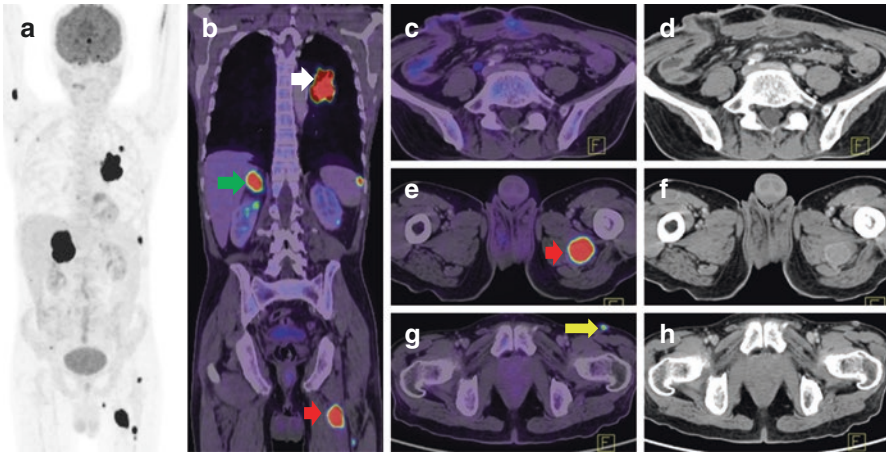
A 64-year-old male patient diagnosed with adenocarcinoma of colon post-surgery and adjuvant chemotherapy, 18F-FDG PET/CT revealed no abnormal lesion in residual bowel (c,d); intensely FDG-concentrating mass lesion in the left hilar region (*white arrow*), right adrenal lesion (*green arrow*), skin nodule (*yellow arrow*), and muscle lesions (*red arrow*). Biopsy from the muscle lesion proved it to be metastatic adenocarcinoma, and second primary in the lung was later confirmed
